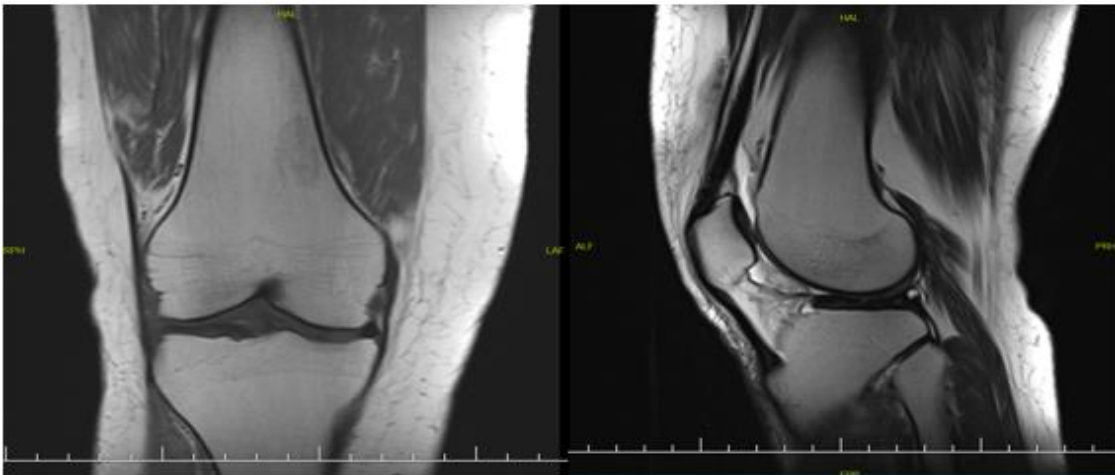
Third case’s knee MRI image
